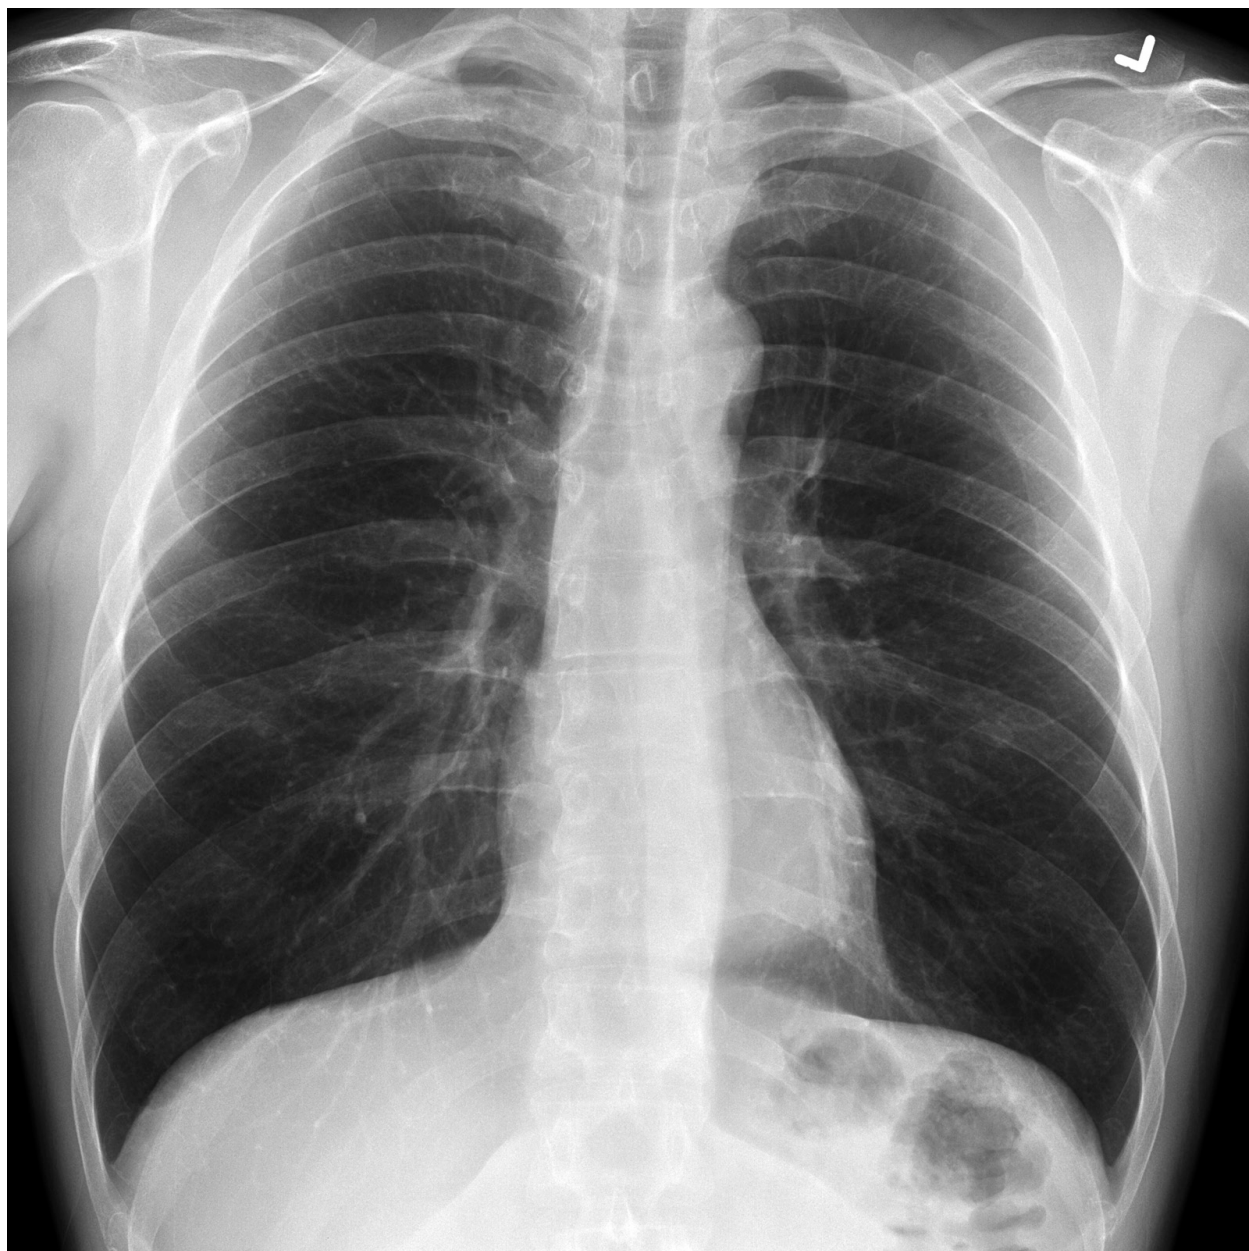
Image Source: Gaillard F. Normal chest x-ray. Radiopaedia.org (Accessed on 29 Oct 2023)
